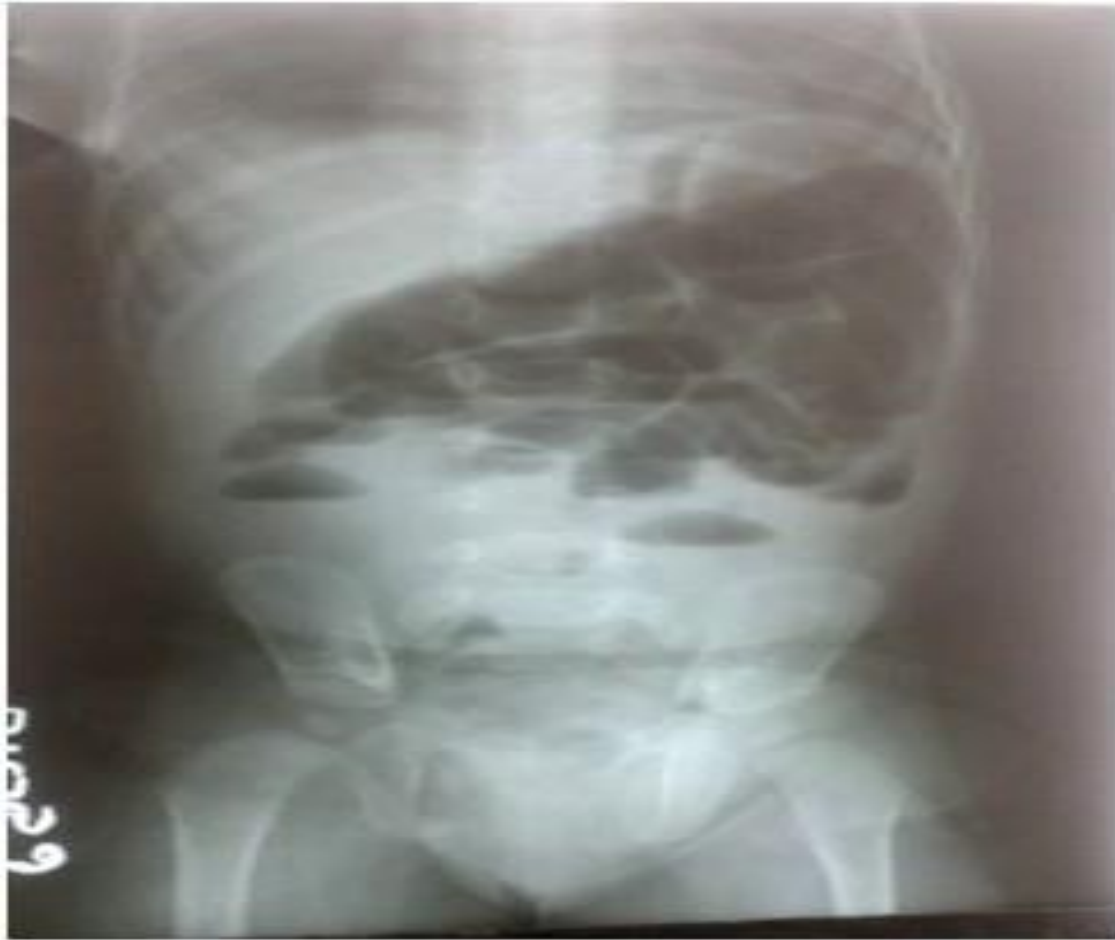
X-ray abdomen showing multiple air fluids level
